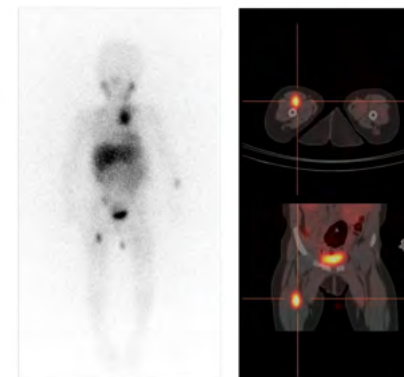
Metastatic neuroblastoma. Planar ^{123}I -MIBG imaging (left panel) demonstrates multiple metastases throughout the body. SPECT/CT (right panel) clearly differentiates between bone marrow and soft tissue lesions.
